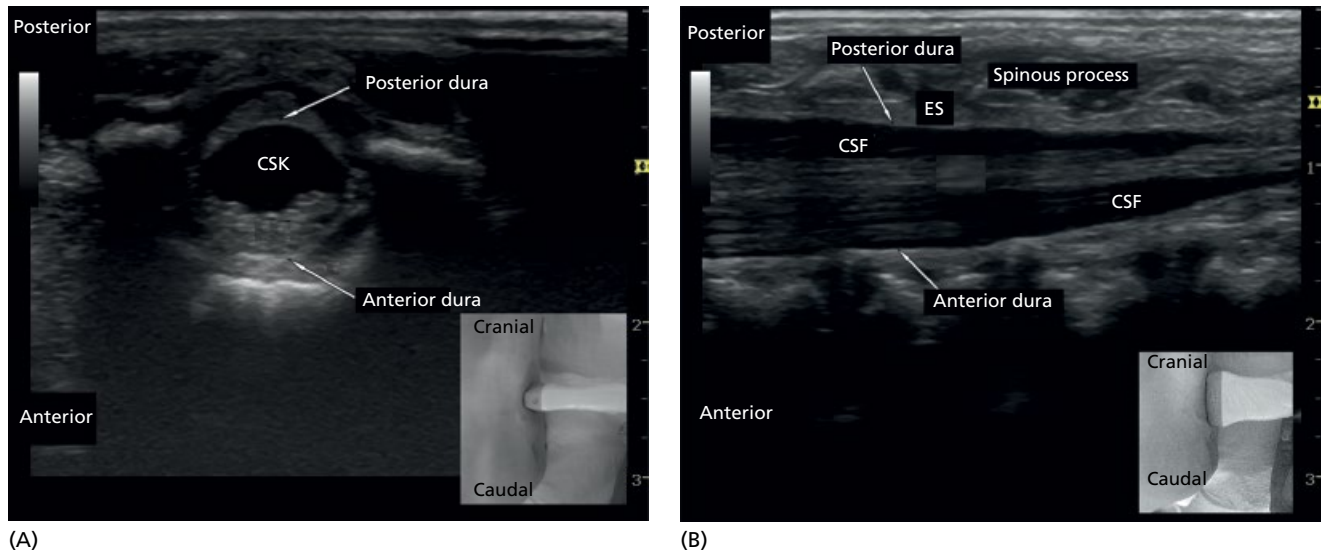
Ultrasound imaging of the epidural region. (A) Transverse view. (B) Paramedian longitudinal view. CSF, cerebrospinal fluid; ES, epidural space. See text for further details.
